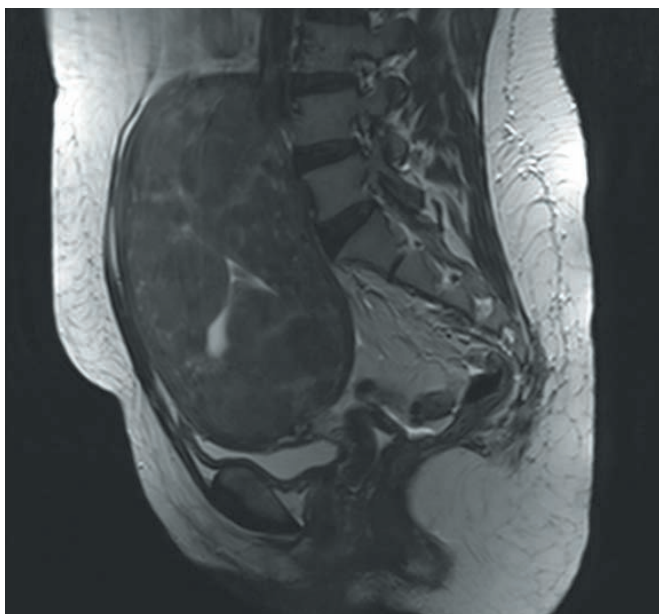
Pre-embolisation sagittal T2-weighted magnetic resonance imaging scan of the pelvis demonstrating large multi-fibroid uterus.
